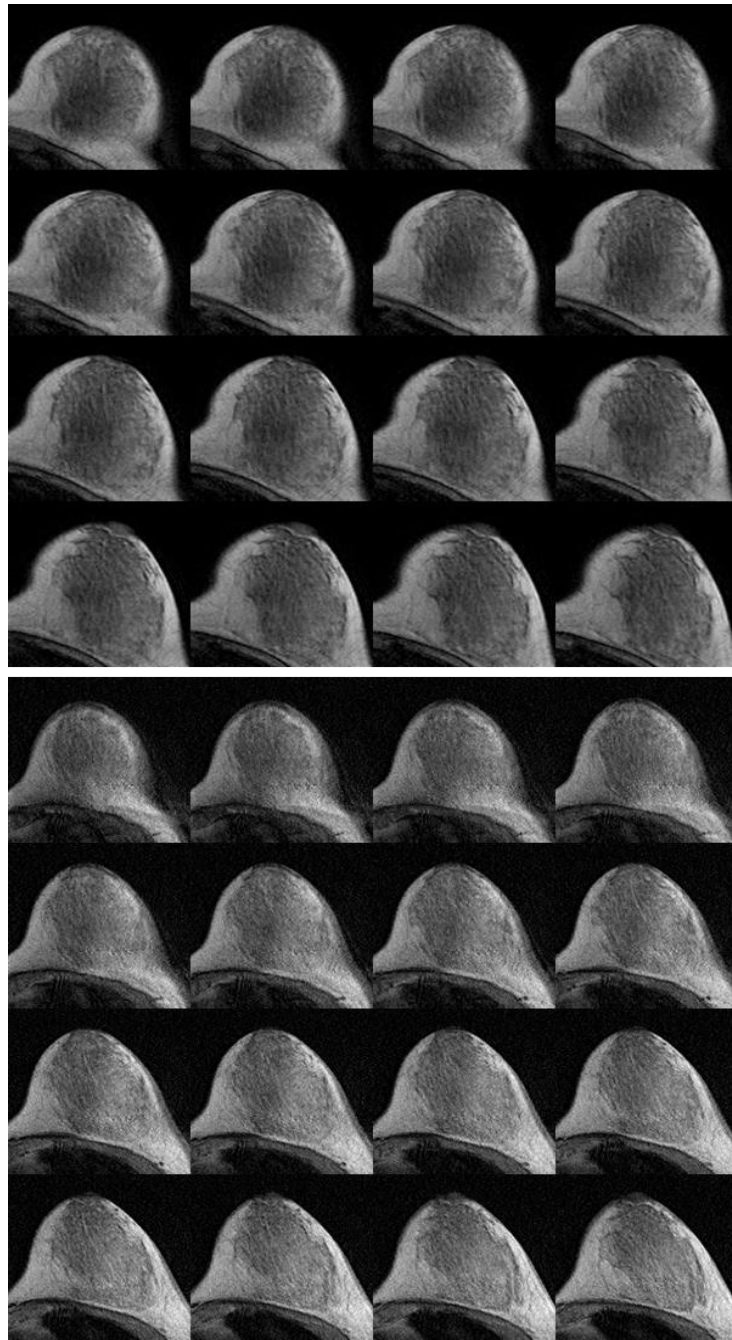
Comparison of T1-weighted MR images acquired using Philips Breast coil (top) and our single channel breast coil (bottom).
